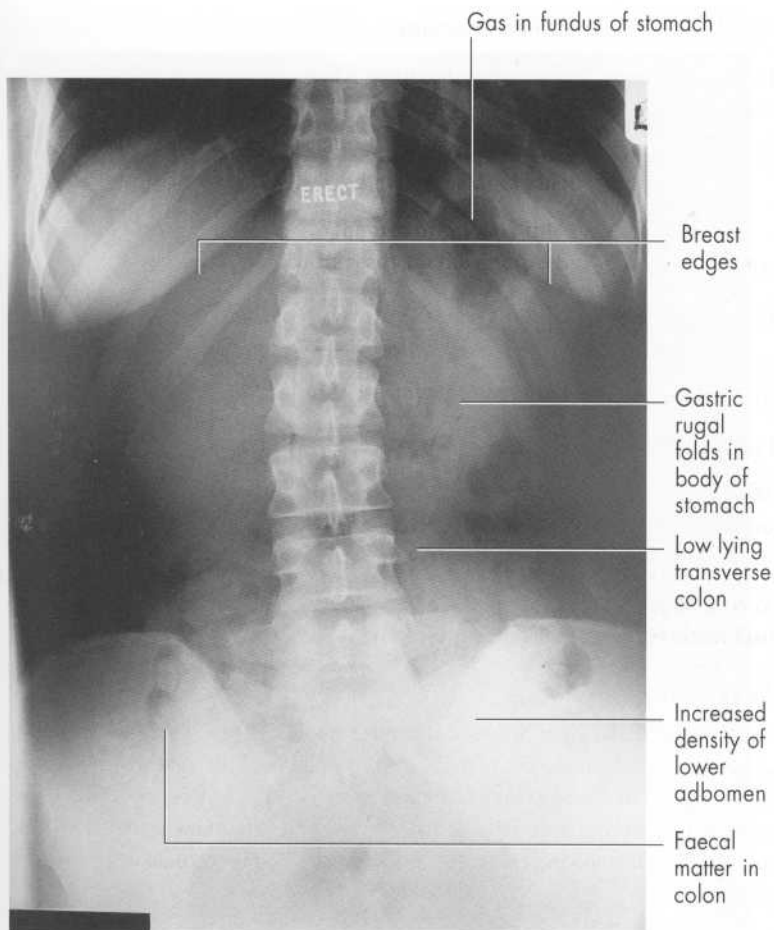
This is a typical normal erect abdominal radiograph of a female patient but there is insufficient fluid to form fluid levels.
